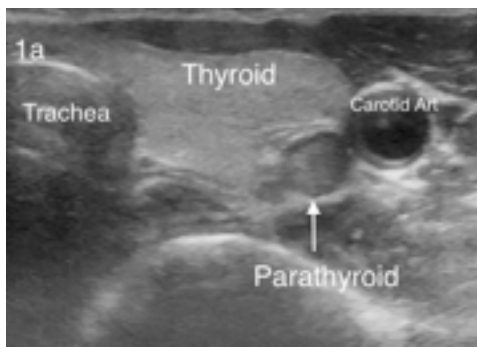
Axial ultrasound of the neck showing a parathyroid adenoma.
